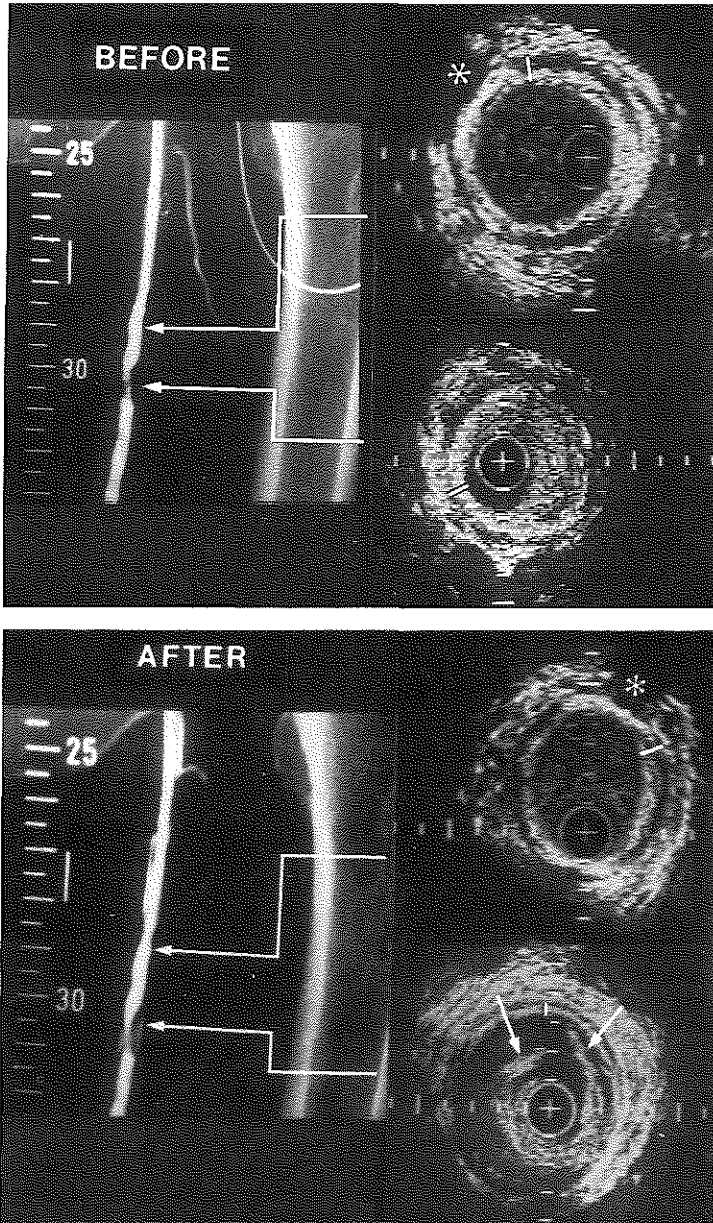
Intravascular ultrasound cross sections obtained at the same levels before (upper panel) and after (lower panel) balloon angioplasty. A dissection is noted angiographically and echographically after (lower panel) balloon angioplasty (bold arrows). Note the unchanged media thickness at level 29 and the reduction in media thickness at level 30 after intervention (media thickness indicated by white marker). Given the orientation of the shadow (level 29, asterisk) before and after intervention, the image is rotated clockwise 15 minutes. Calibration=1 mm.
